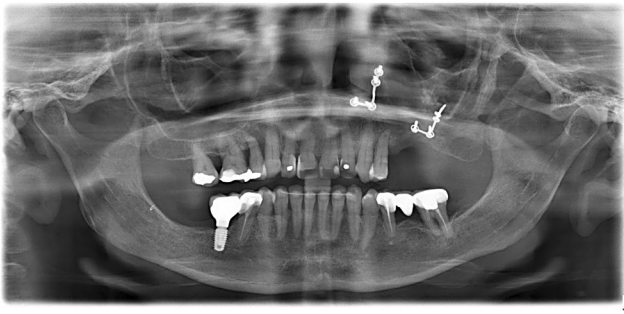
Preoperative orthopantomogram showing a left maxillary sinus hyperdense formation and the two plates with respective screws.
